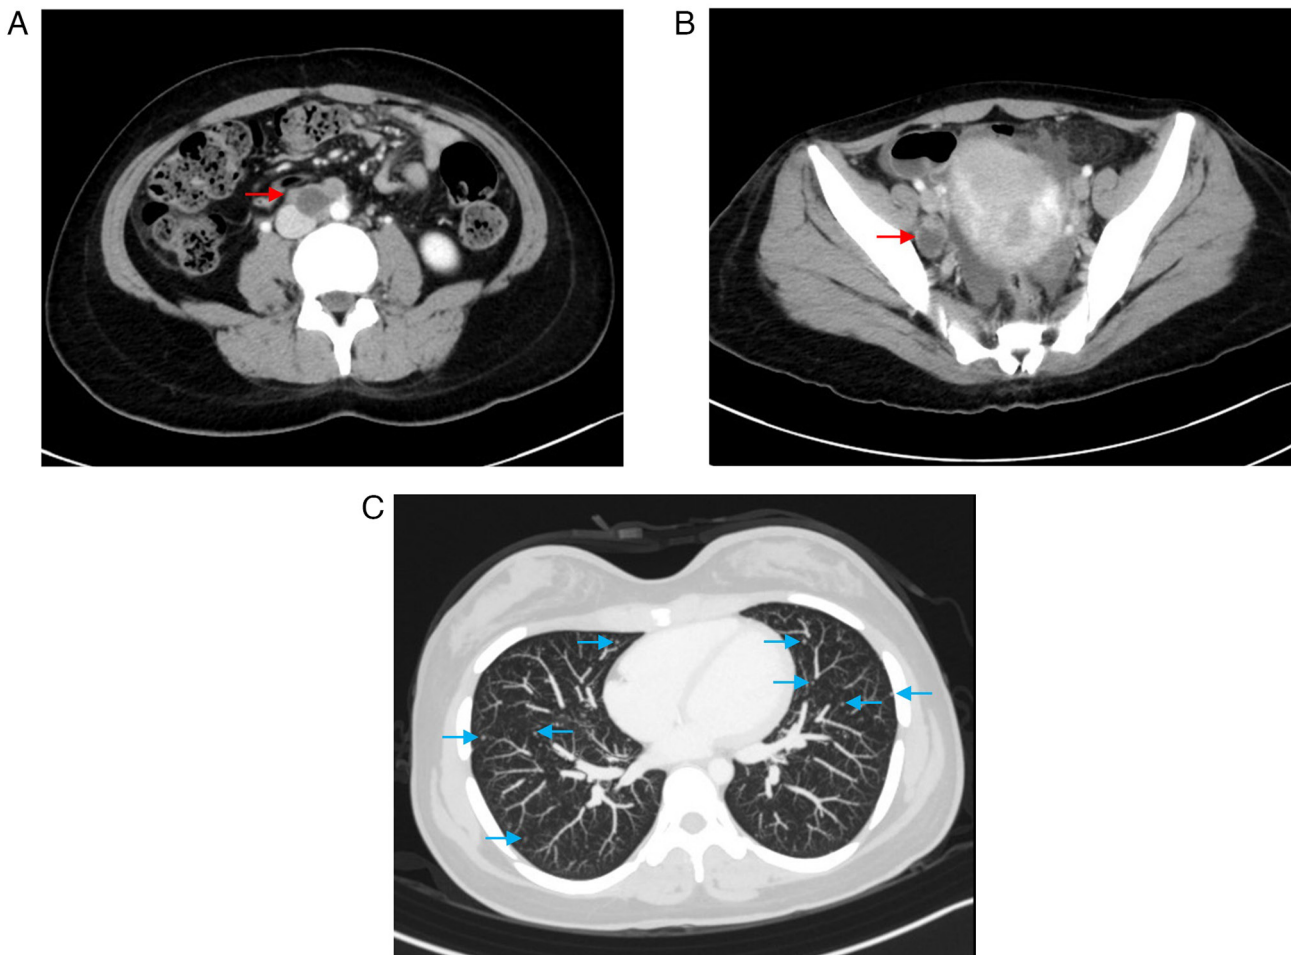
Computed tomography findings. (A) Enlarged para-aortic lymph nodes (red arrow). (B) Enlarged pelvic lymph nodes (red arrow). (C) Multiple pulmonary nodules (blue arrows). These findings were suggestive of metastatic disease.
